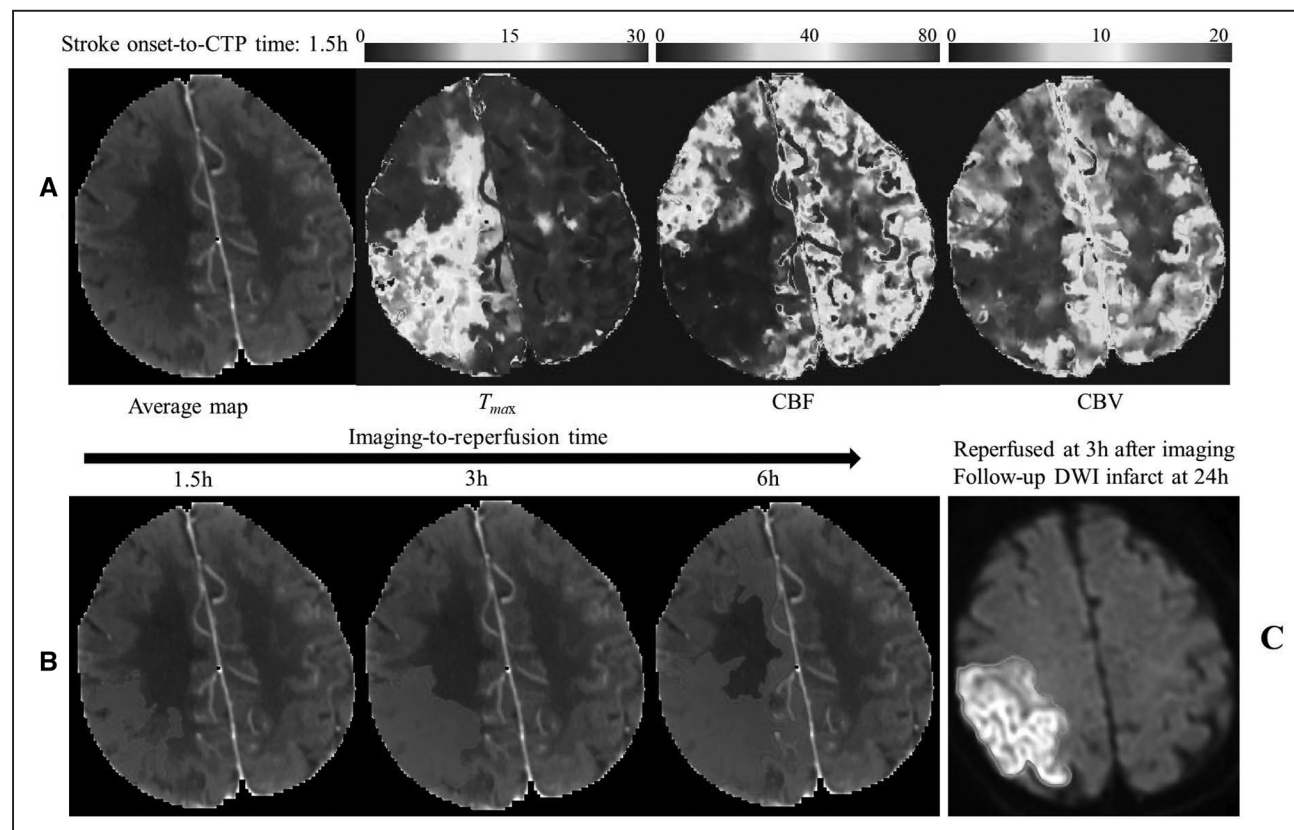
Prediction results by different imaging-to-reperfusion times using the computed tomography perfusion (CTP)-based machine learning model.
